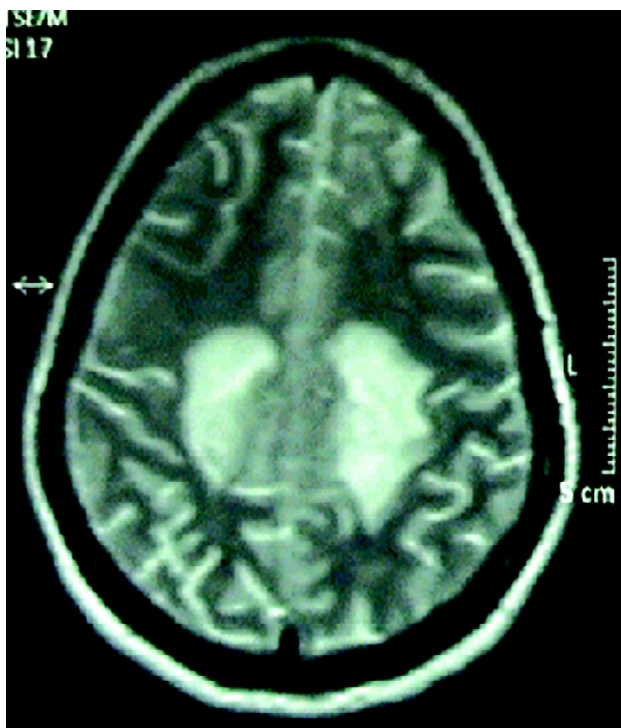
Follow-up MRI (17/04/09) – Axial T2 weighted image (A) showing B/L parasagittal white matter hyper-intensities and T1 weighted contrast image (B) showing two small ring-enhancing lesions in the same area.
